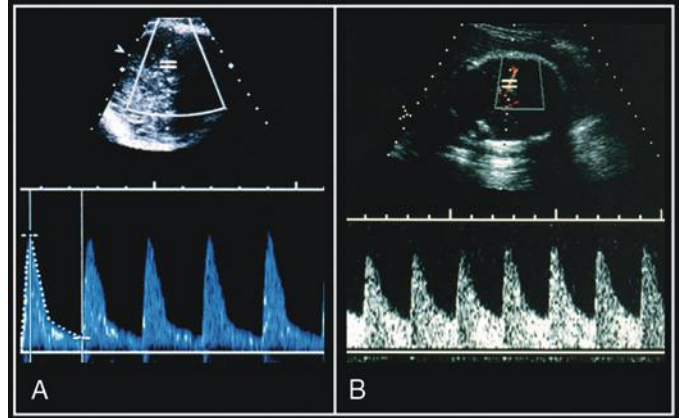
Doppler waveforms of the middle cerebral artery in a normal fetus (A) and in a hypoxemic fetus (B). Note the increase in end-diastolic velocity in fetus B resulting from a low-impedance cerebral circulation as part of the brain-sparing reflex.
